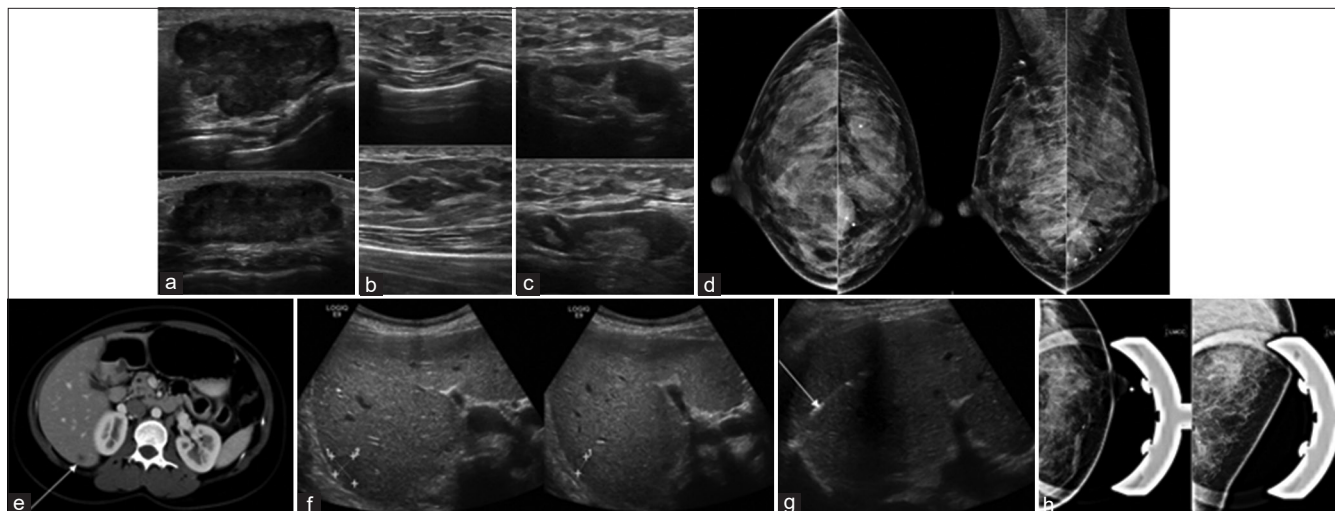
A 32-year-old woman, 9 weeks pregnant, presented for further evaluation of a left breast mass at the 6 o'clock position. Initial evaluation was performed with a breast ultrasound. (a) Longitudinal (top) and transverse (bottom) ultrasound of the palpable abnormality at the 6 o'clock position, 7 cm from the nipple, demonstrates an irregular hypoechoic $2.8 \times 1.6 \times 3.8$ cm mass (short arrow). (b) Longitudinal (top) and transverse (bottom) ultrasound of the left breast at the 9 o'clock position, 1 cm from the nipple, demonstrates irregular hypoechoic mass, measuring $0.7 \times 0.5 \times 0.8$ cm (long arrow). (c) Longitudinal (top) and transverse (bottom) ultrasound of the left axilla demonstrates an abnormal lymph node with increased cortical thickness (arrow). (d) Craniocaudal (right) and mediolateral oblique (left) images of the bilateral breasts demonstrate that the palpable abnormality in the left breast at the 6 o'clock position, 4 cm from the nipple, correlates with a round mass with indistinct margins (arrow). There was no mammographic correlate for the left breast mass at the 9 o'clock position. Ultrasound-guided core needle biopsy of the left breast mass at the 6 o'clock position revealed invasive ductal carcinoma. Ultrasound-guided core needle biopsy of the left breast mass at the 9 o'clock position revealed ductal carcinoma *in situ*. Ultrasound-guided fine-needle aspiration of the left axillary lymph node demonstrated metastatic carcinoma. (e) CT of the chest and the abdomen was performed for the evaluation of metastatic disease and demonstrates a 1.4 cm hypodense lesion in the right lobe of the liver (arrow) that was suspicious for metastasis. (f) Ultrasound of the abdomen demonstrated a 1.4 cm hypodense mass in the right lobe of the liver (calipers, short arrow). (g) Ultrasound-guided core needle biopsy (long arrow) of the liver mass demonstrated metastatic carcinoma. (h) The patient received five cycles of chemotherapy and delivered a healthy baby. Left breast craniocaudal (left) and lateral medial (right) magnification views were obtained after completion of chemotherapy and demonstrate interval development of pleomorphic calcifications (oval) in the inferior left breast and resolution of the previously visualized mass, consistent with tumor necrosis and response to chemotherapy.
